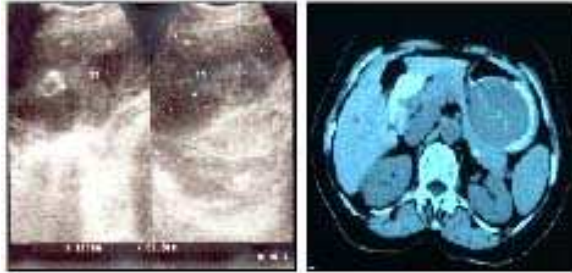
(A). Abdominal ultrasound showed inhomogeneous hypoechoic mass, clear margin enlarge to the left with size 11.7 x 6.2 cm (B). CT scan abdomen with contrast was performed and showed large mass in epigastrium to left hypochondrium, filling defect with soft tissue density round/oval shape
